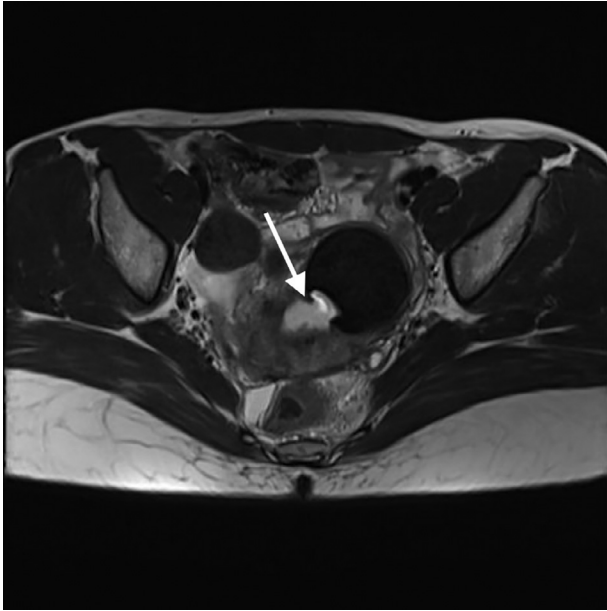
Postembolization state (2018) T2-weighted MRI axial view shows decreased size of myoma and connection to endometrium (arrow) compare to Figure 1.
